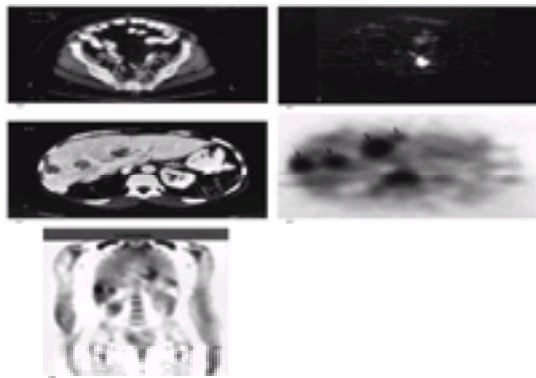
(a) Anatomic study of the pelvis showing lesion compared with scar (arrow) in patient with colorectal carcinoma; (b) FDG-PET image of the same location showing a hypermetabolic lesion (arrow) consistent with a recurrence. (c) Patient with colorectal carcinoma with numerous lesions on CT scan of liver; (d) corresponding FDG-PET image shows many hypermetabolic lesions (arrow) consistent with liver metastasis. (e) Coronal whole-body FDG-PET image of the above patient showing the capacity of newer scanners to image the entire body.
